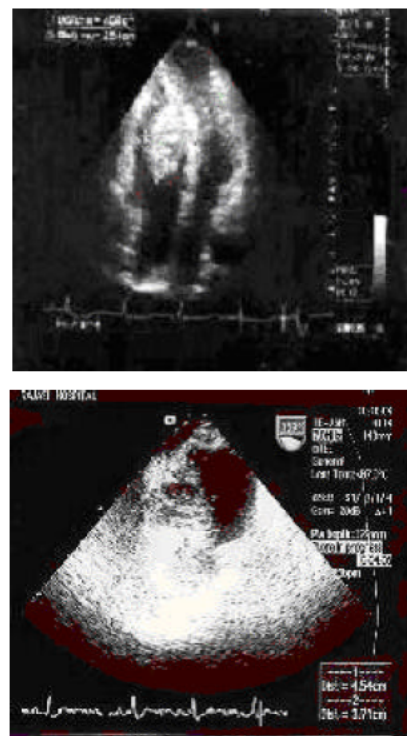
Left: Transthoracic apical 4 chamber view show large intramural nonhomogenous RV mass which occupies RV cavity. Right: Transesophageal view show large septated echolucent cystic RV mass with small echodense masses within it (daughter cyst)
